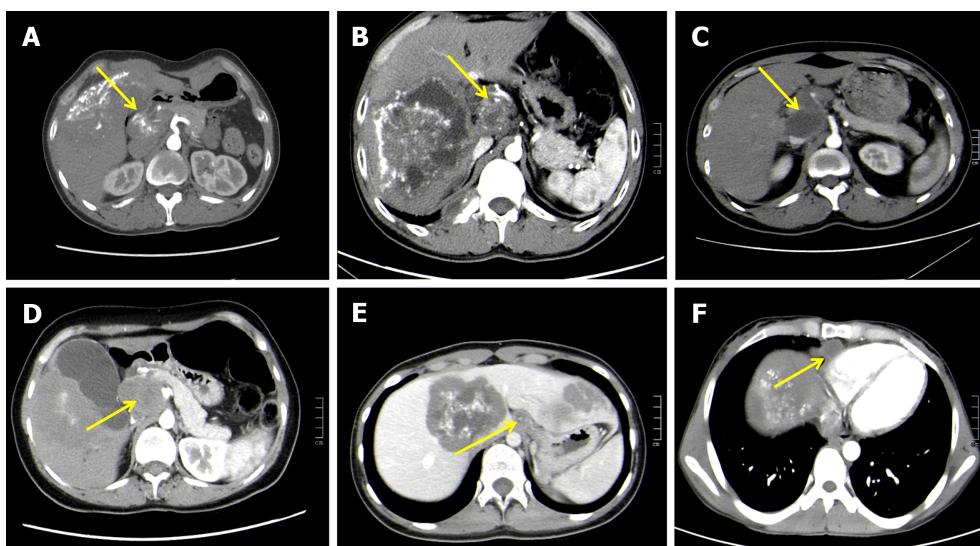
Computed tomography findings of lymph node metastasis in hepatic alveolar echinococcosis. A: An enlarged mixed-density lymph node with multiple nodular, eggshell calcifications next to the portal vein in the first hepatic portal area and an unenhanced liquefied necrotic area in the lesion on an enhanced scan; B: A roundish mixed-density mass next to the common hepatic artery, with multiple sand-like, nodular calcifications within the lesion, with mild to moderate enhancement of the lesion on an enhanced scan and a hypoenhanced liquefied necrotic area within the lesion; C: Enlarged lymph nodes were observed at the bifurcation level of the splenic artery and common hepatic artery on the right side of the celiac trunk, with uniform density within them, and patchy but unenhanced areas of liquefied necrosis were seen within the lesion on enhancement scans; D: A mixed-density mass in the interstitial space of the abdominal aorta posterior to the pancreatic head with a speckled high-density shadow and a patchy slightly low-density shadow, heterogeneous enhancement on an enhanced scan, and no significant enhancement in the slightly low-density liquefied necrotic area within the lesion; E: An enlarged heterogeneously dense lymph node with nodular foci next to the abdominal aorta, with a mild to moderate enhanced lesion edge on an enhanced scan and no enhancement within the lesion; F: A roundish, slightly hypointense shadow in the right diaphragmatic angle with circular enhancement at the lesion edge on an enhanced scan and no significant.
